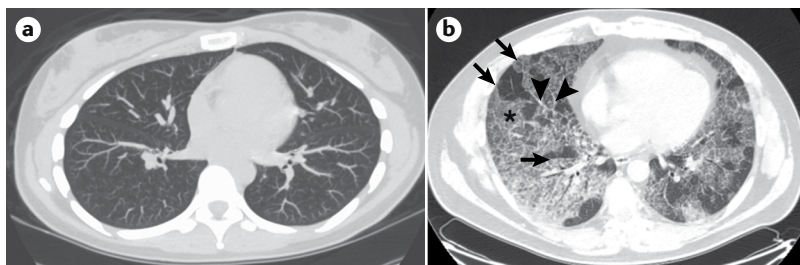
Radiological findings in PAP. CT scans of the chest in a healthy person (panel a) and a patient with autoimmune pulmonary alveolar proteinosis (PAP) (panel b). Note the ground-glass opacification (asterisk) and superimposed, angulated septal thickening (arrowheads), a pattern referred to as ‘crazy paving’, which is characteristic but not diagnostic of autoimmune PAP. Note also the geographical appearance (arrows), which arises from the juxtaposition of severely affected (lighter-appearing) secondary lobules adjacent to more-normal secondary lobules (darker-appearing).
